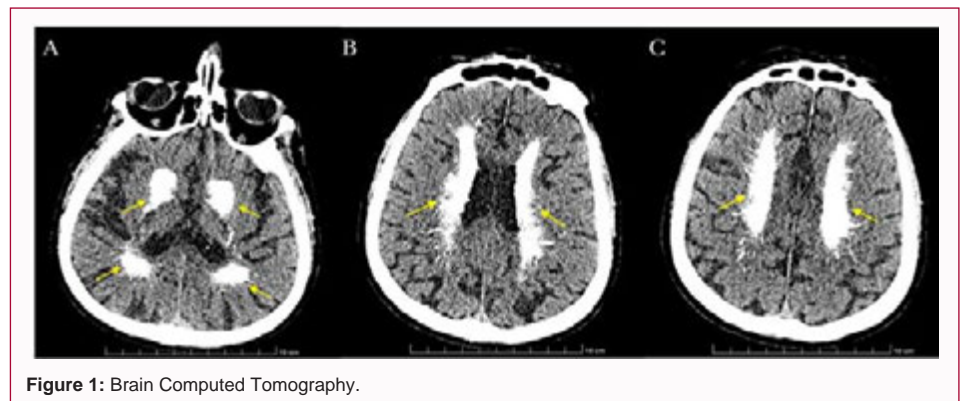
Brain Computed Tomography.
